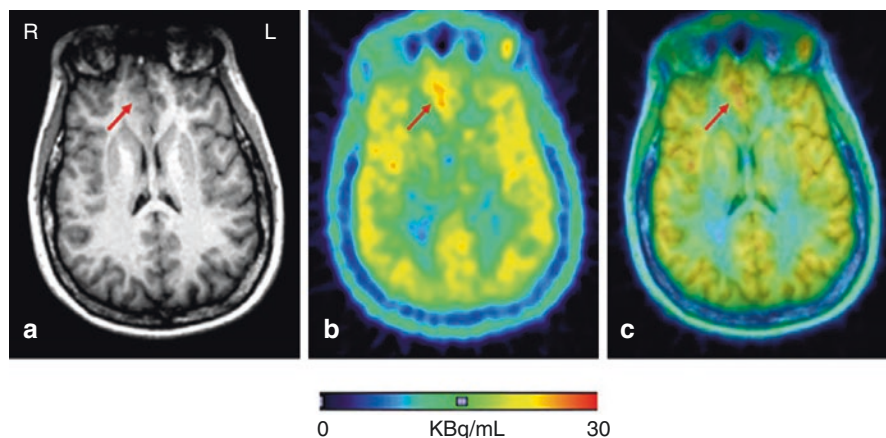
(a) Structural MRI showing region of increased right frontal signal suggestive of focal cortical dysplasia. (b) TSPO-PET scan showing increased ligand binding. In the same region consistent with inflammation, (c) merged images. Reprinted from Dickstein et al. *Epilepsia* 2019;60:1248–1254
